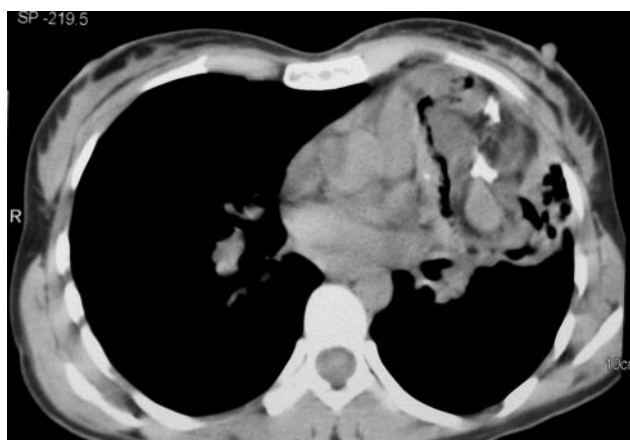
Computed tomogram showing a heterogeneous mass lesion in the left upper lobe, with calcification, fatty tissue, and solid and cystic components.
